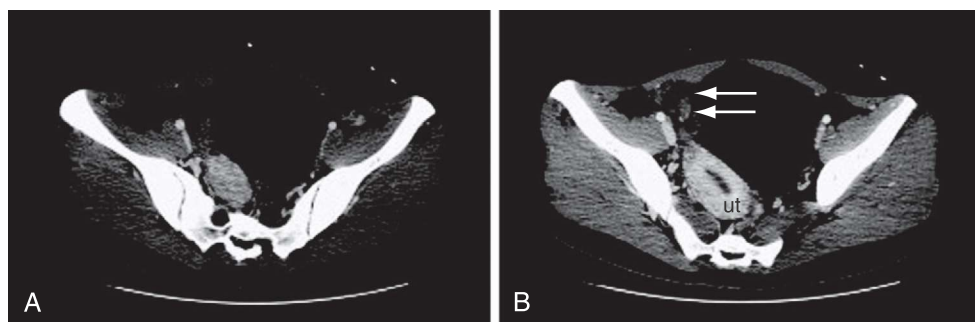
A and B, Computed tomography scans of the pelvis of a patient with ovarian torsion. Findings include a thickened fallopian tube, associated adnexal mass (arrows in B), and deviation of the uterus (ut) toward the twisted adnexa. (From Andreotti RF, Shadinger L, Fleischer A: The sonographic diagnosis of ovarian torsion: Pearls and pitfalls. *Ultrasound Clin* 2:155, 2007.)
